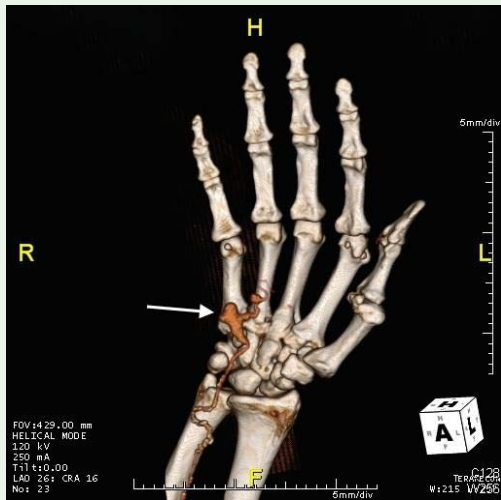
CT with contrast (3D reconstruction) of right hand showing ulnar artery aneurysm (arrow).
